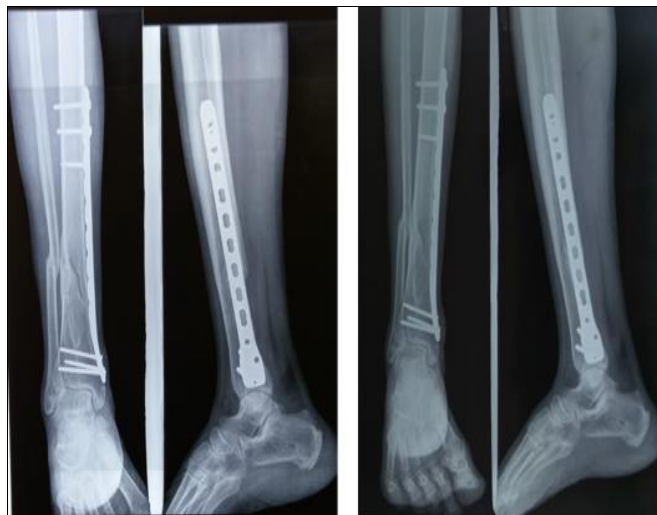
(a):Radiograph - 6th week
